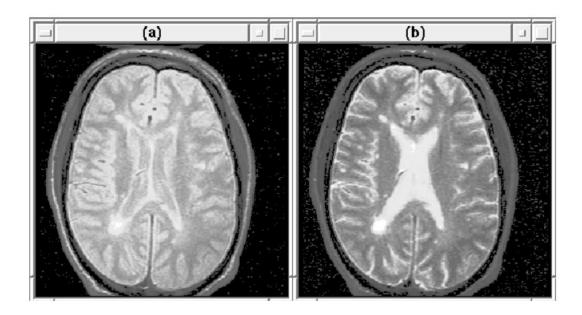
(a) A proton density (PD) weighted MR image slice. (b) The same T2-weighted slice.
